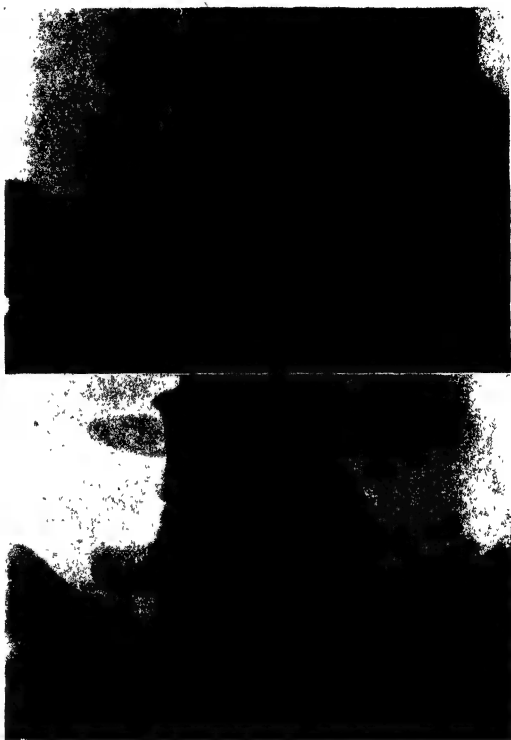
Metastasis from carcinoma mamma in transverse process of 5th lumbar vertebra. Radiographed because of severe backache. No bone change shown in first radiogram, but clearly shown (destruction of transverse process) in "repeat" radiogram three and a half months later.
